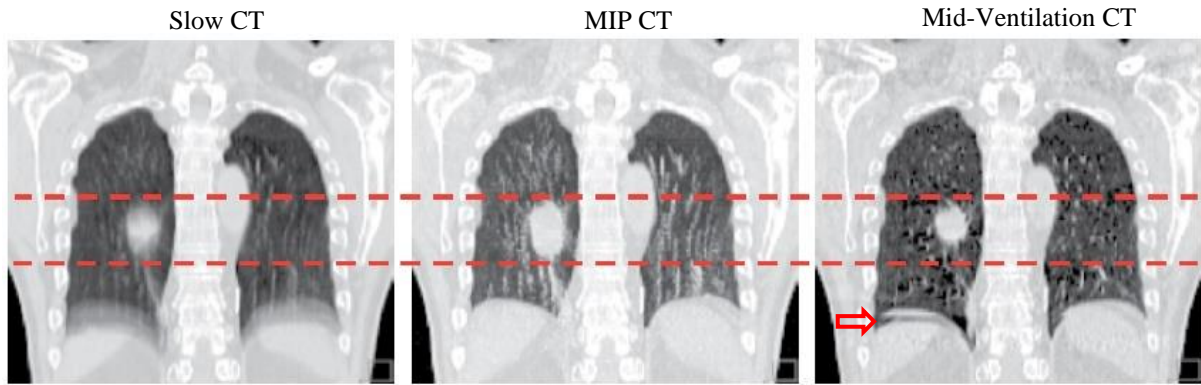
Comparison of a Slow CT, a Maximum Intensity Projection (MIP) CT and a Mid-Ventilation CT for the same patient [15]. The tumour appears larger on the MIP CT when compared to the Mid-V CT as indicated by the red lines. The boundary between the tumour and soft tissue can be more difficult to distinguish on the Slow CT than in the Mid-V CT. The clarity of the tumour boundaries is visually improved on the Mid-V CT but it has more noise and is more prone to motion artefacts as shown by the distortion of the dome at the lung–diaphragm interface (red arrow).
